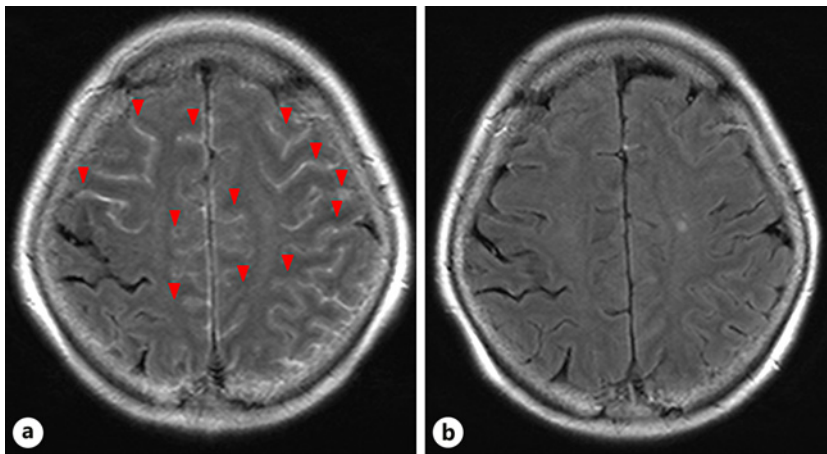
Contrast-enhanced FLAIR MRI of the brain. a Imaging before steroid treatment revealing contrast enhancement along the cerebral sulcus (red arrowheads). b Image taken 8 days after commencing steroid treatment indicating the contrast effect along the cerebral sulcus disappeared.
